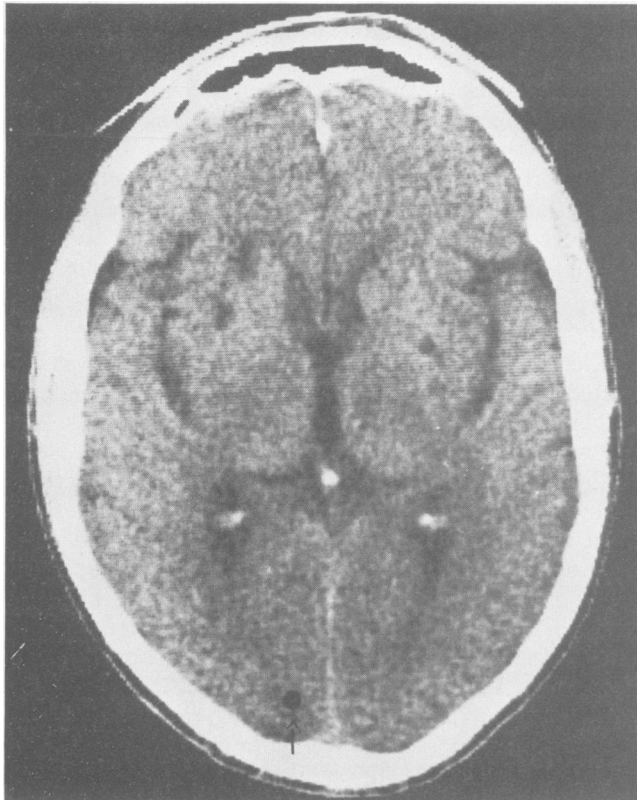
Computed tomogram of the patient in case 1 obtained 12 hours after the onset of symptoms, showing an air-density lesion (arrow). A repeat scan 5 days later showed resolution of the air-density lesion with a residual area of low attenuation.
